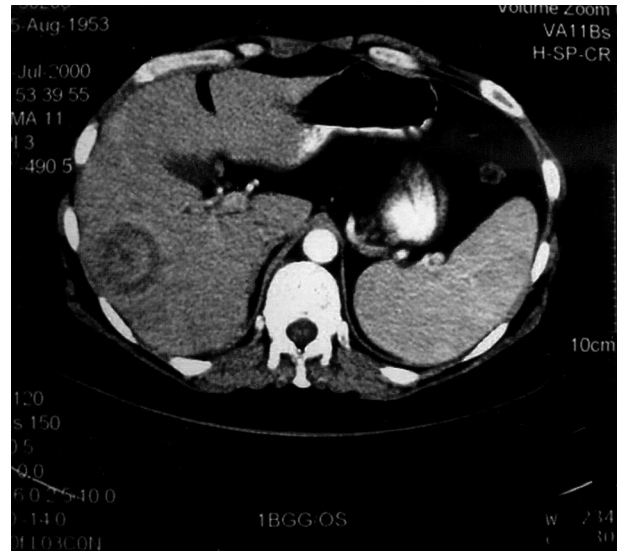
CT-scan of the abdomen : 'bull's eye' lesion in the right liver lobe, measuring 4.8 by 2.5 cm.
